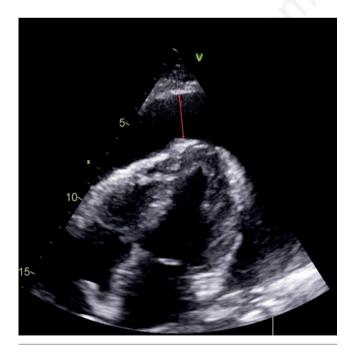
(Video 1). Echocardiogram showing massive pericardial effusion (red arrow) with normal left ventricle systolic function, and no regional wall motion abnormalities.
